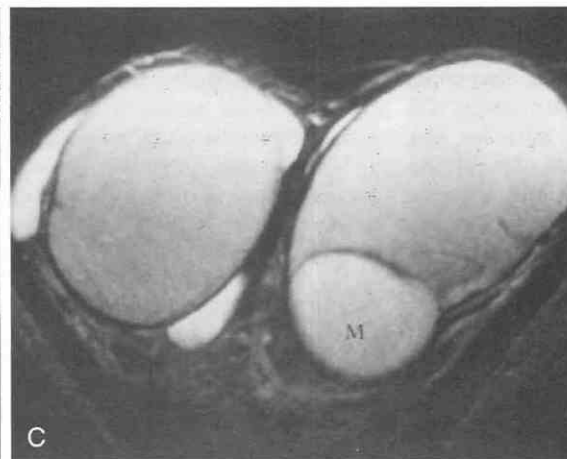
MRI differentiation of a palpable, left-sided testicular mass in a 24-year-old man. *A*, An ultrasound examination had demonstrated a left testicular mass (M) that showed diffuse moderate echogenicity and was thought to be a solid lesion. Increased through-transmission, however, can be noted. *B*, T1-weighted, spin-echo image (TR = 500 msec, TE = 15 msec), shows a well-circumscribed mass (M) of low signal intensity. *C*, T2-weighted, fast spin-echo image (TR = 4000 msec, TE_{eff} = 115 msec), shows the mass (M) to have very high signal intensity. The appearance of the mass in *B* and *C* is consistent with that of a cyst, and pathologic examination showed an intratesticular left-sided epidermoid cyst. A small right-sided hydrocele can be seen in *C*. TE_{eff}, effective echo time.
